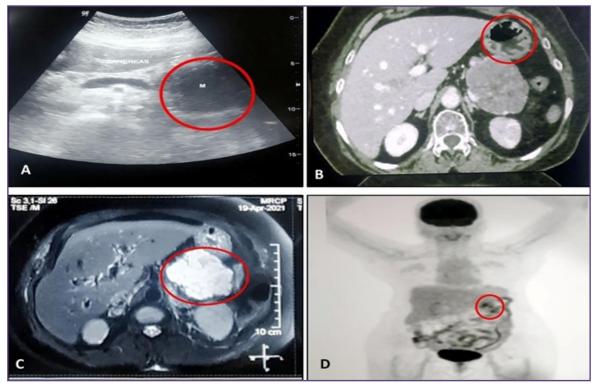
Imaging findings of the patient (red circle indicates the lesion) A: USG B: Plain CT whole abdomen C: MRCP D: PET CT
